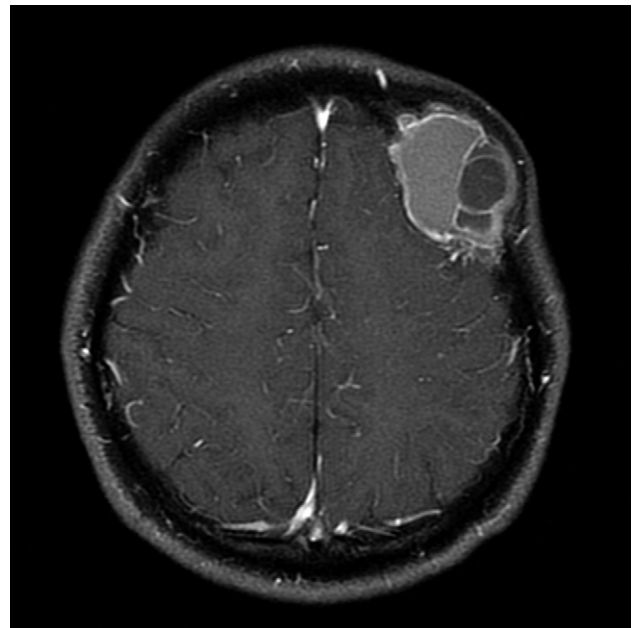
Preoperative 3.0-T magnetic resonance imaging. Gadolinium enhanced fat-suppressed T1-weighted gradient-echo sequence shows a well circumscribed, intradiploic, multilocular, cystic tumour with marginal and septal enhancement of the tumour.
